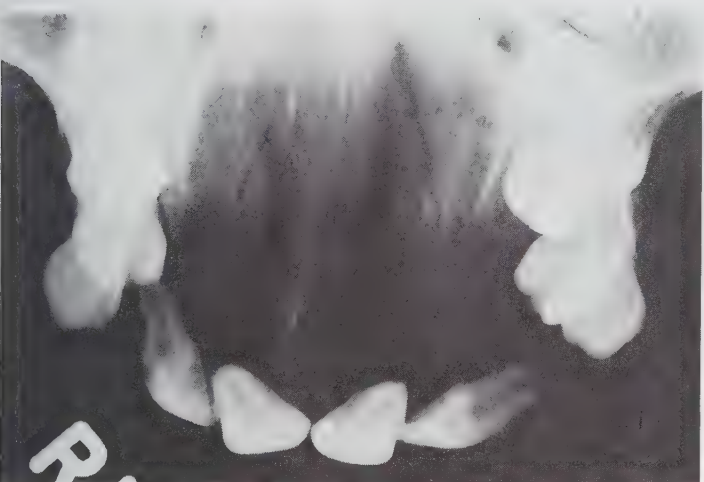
Occlusal radiograph showing extent of radiolucent lesion in the palatal aspect.
